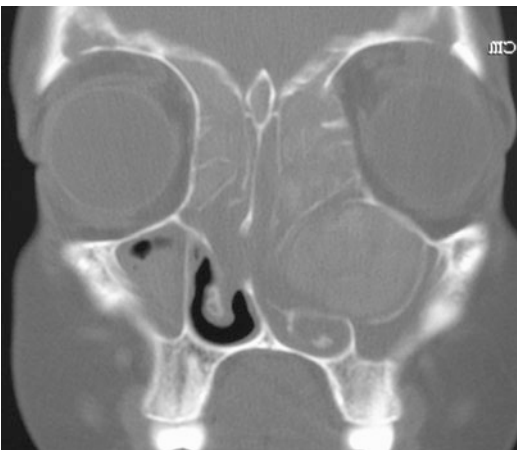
Coronal non-contrast CT image with bone windowing from a patient with AFS. Faint hyperattenuation of sinus contents is seen with left ethmoid expansion and mucocoele impinging on the left maxillary sinus
